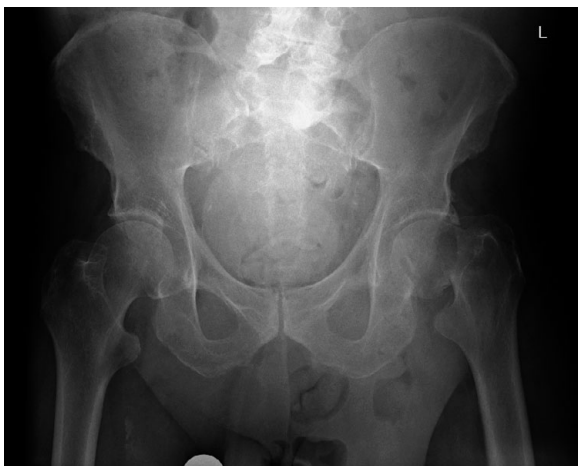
Anteroposterior radiograph (AP) left hip
